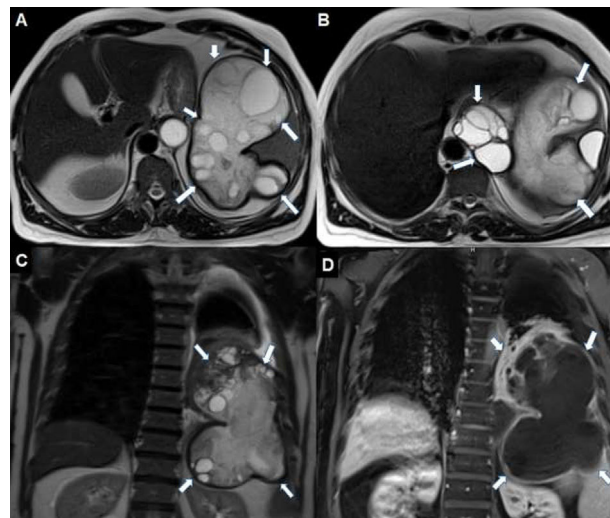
Axial T2-weighted MRI (A and B, respectively) show transdiaphragmatic lesion at the spleen level and multiloculated cystic lesion (arrows) with mediastinal extension at the level of esophageal hiatus. The presence of daughter vesicles in the cysts and the presence of relatively hypointense thick walls are typical features of the hydatid cyst. In the coronal T2-weighted (C) MR image, the cystic lesion (arrows) substantially fills the left hemithorax. The coronal image also reveals minimal pleural effusion. Postcontrast coronal T1-weighted (D) MR image reveals contrast enhancement (arrows) at the lesion's periphery. Moreover, the left lower lung is seen compressed by the cyst.
